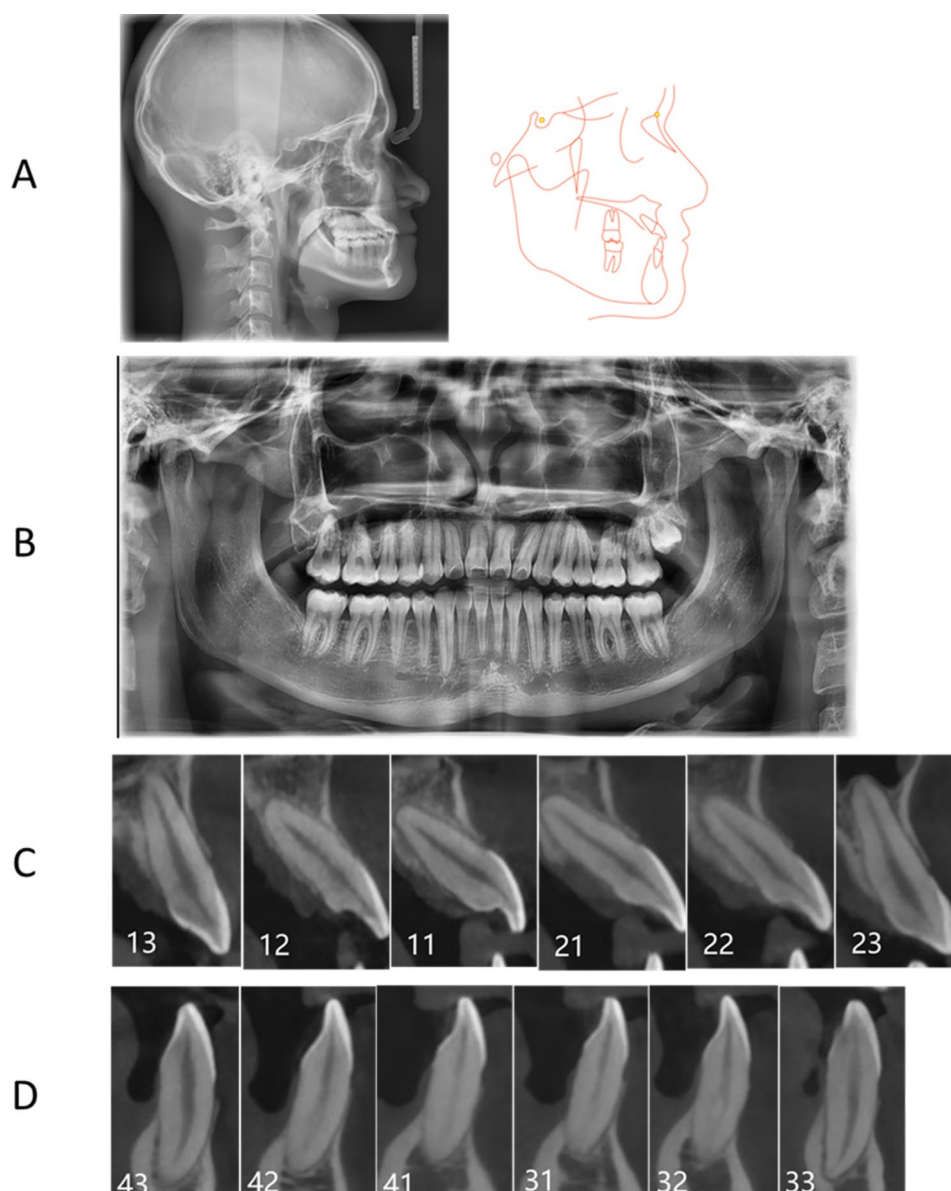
(A) Posttreatment lateral cephalometric radiograph; (B) panoramic radiograph; (C) CBCT imaging of the maxillary anterior area; and (D) CBCT imaging of the mandibular anterior area after treatment
